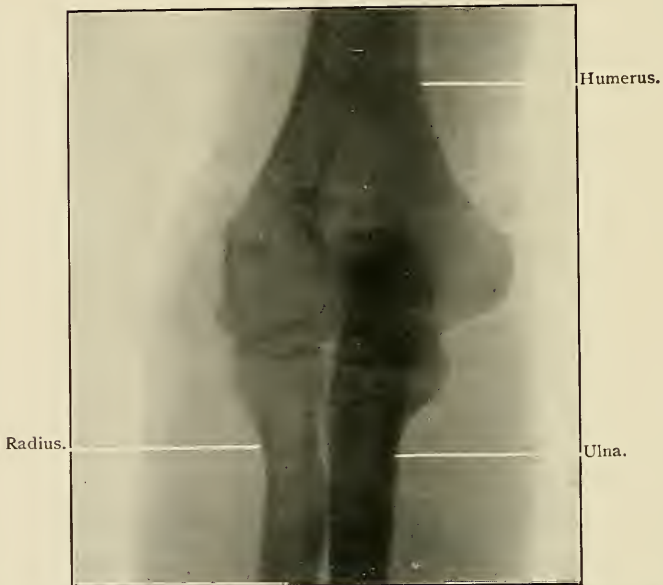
X-ray. Anteroposterior view of the extended elbow of a boy eleven years old. When about six years old he suffered a compound separation of the lower epiphysis of the humerus. Four and one-half to five years after the accident all movements are normal. The carrying angle is slightly less than normal on the injured side.
